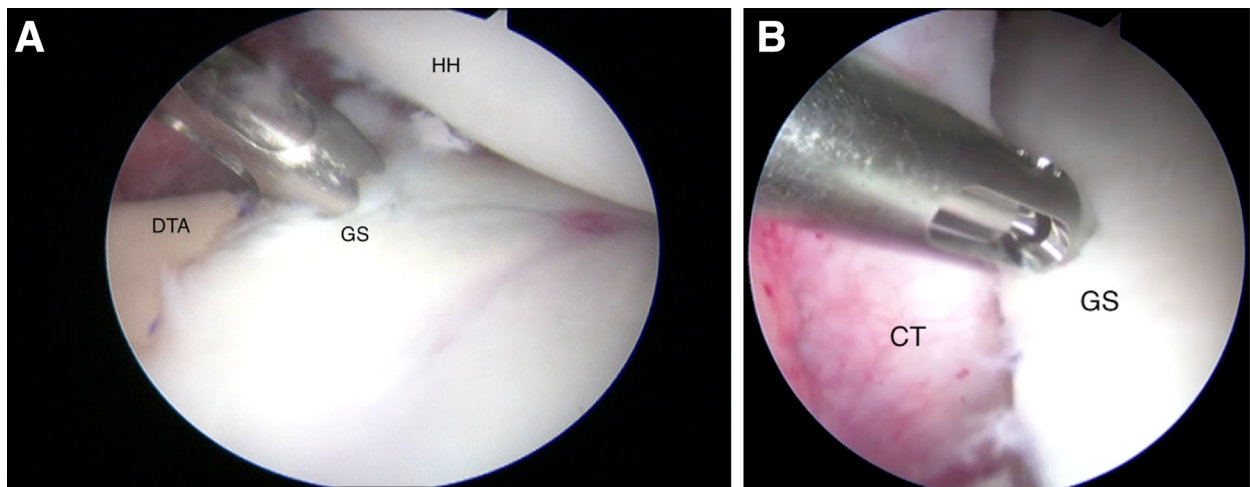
Two single-loaded Q-FIX suture anchors are placed on the anterior portion of the glenoid, at the 6 o'clock and the 3 o'clock locations, respectively. The 6 o'clock anchor is placed first through the anteroinferior portal. Then one of the suture limbs is brought through the posterior portal using a suture retriever, and the other limb remains through the anteroinferior portal. After that, the 3 o'clock anchor is inserted, and one suture limb is brought to the posterior portal using the suture retriever. A view from the anterosuperior portal on the right shoulder: (A) inferior anchor and (B) superior anchor. CT, capsular tissue; DTA, distal tibial allograft; GS, glenoid surface; HH, humeral head.
